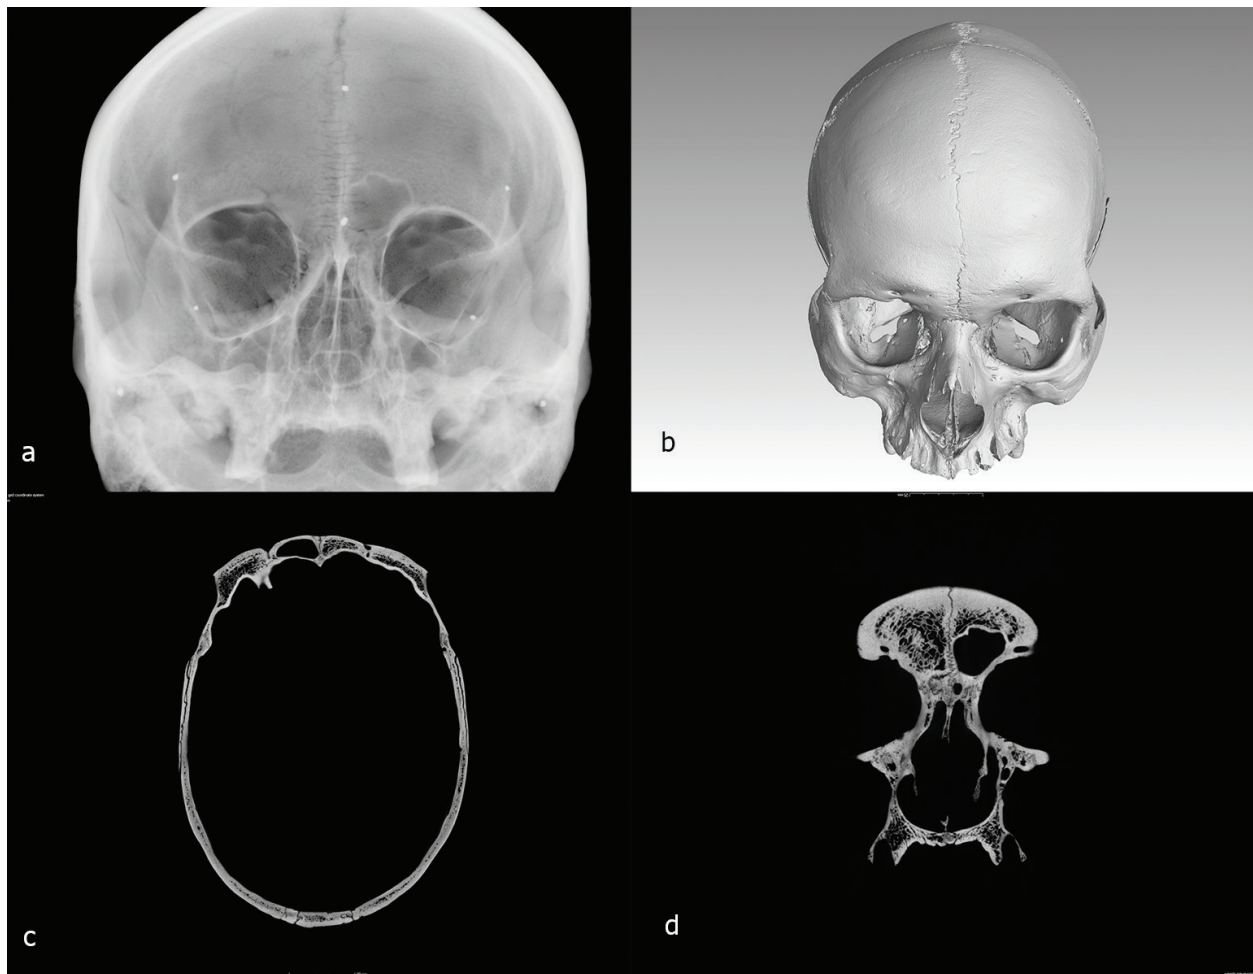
Metopic skull of adult male with aplasia of the right FS: (a) industrial digital radiograph in Caldwell's view; (b) 3D volume representation obtained after scanning with industrial μ CT; (c) axial tomogram at the level of FS; and (d) coronal tomogram at the level of FS.
